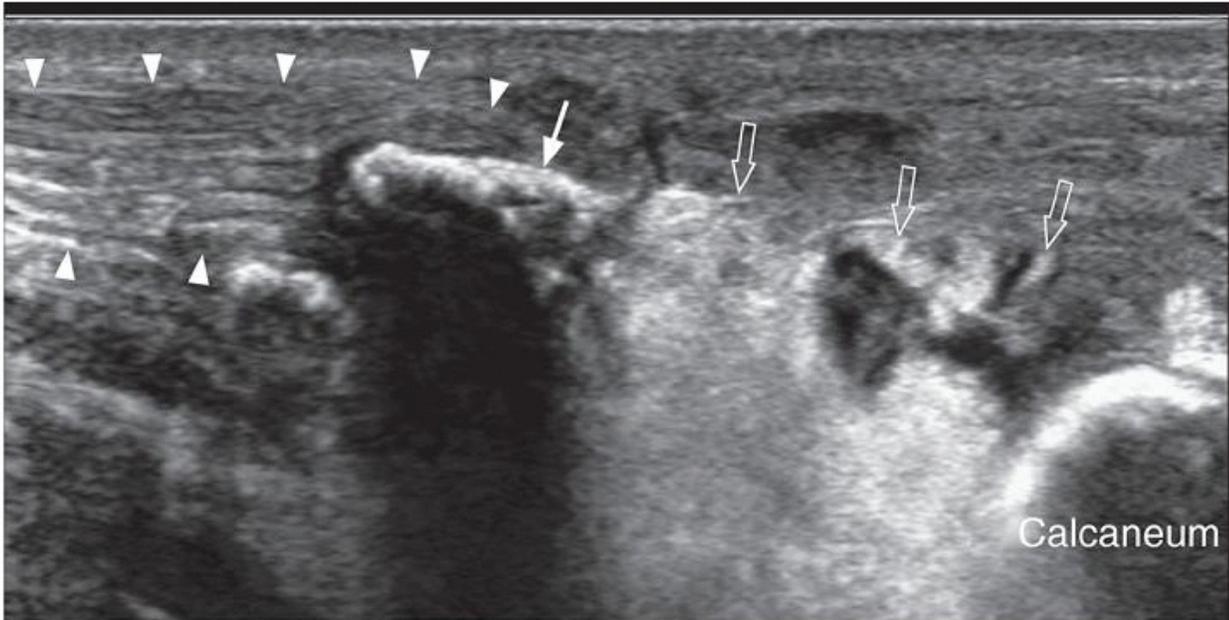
Longitudinal ultrasound showing Achilles fracture avulsion from calcaneal insertion. The Achilles tendon (arrowheads) is attached to a large fragment of bone (closed arrow) avulsed from the calcaneum. The intervening gap is filled with echogenic fat and hematoma (open arrows).
